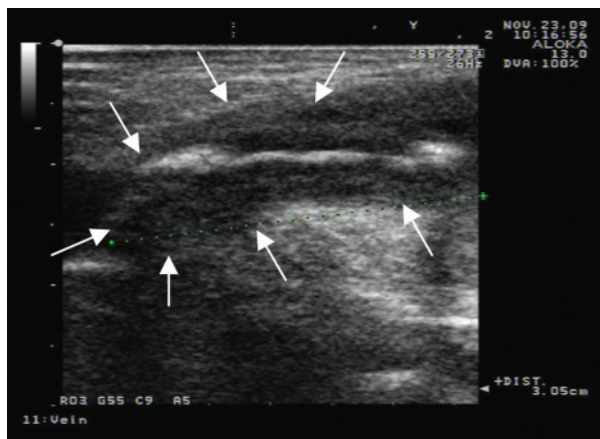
Longitudinal ultrasonography view of the incarcerated appendix (arrows)
